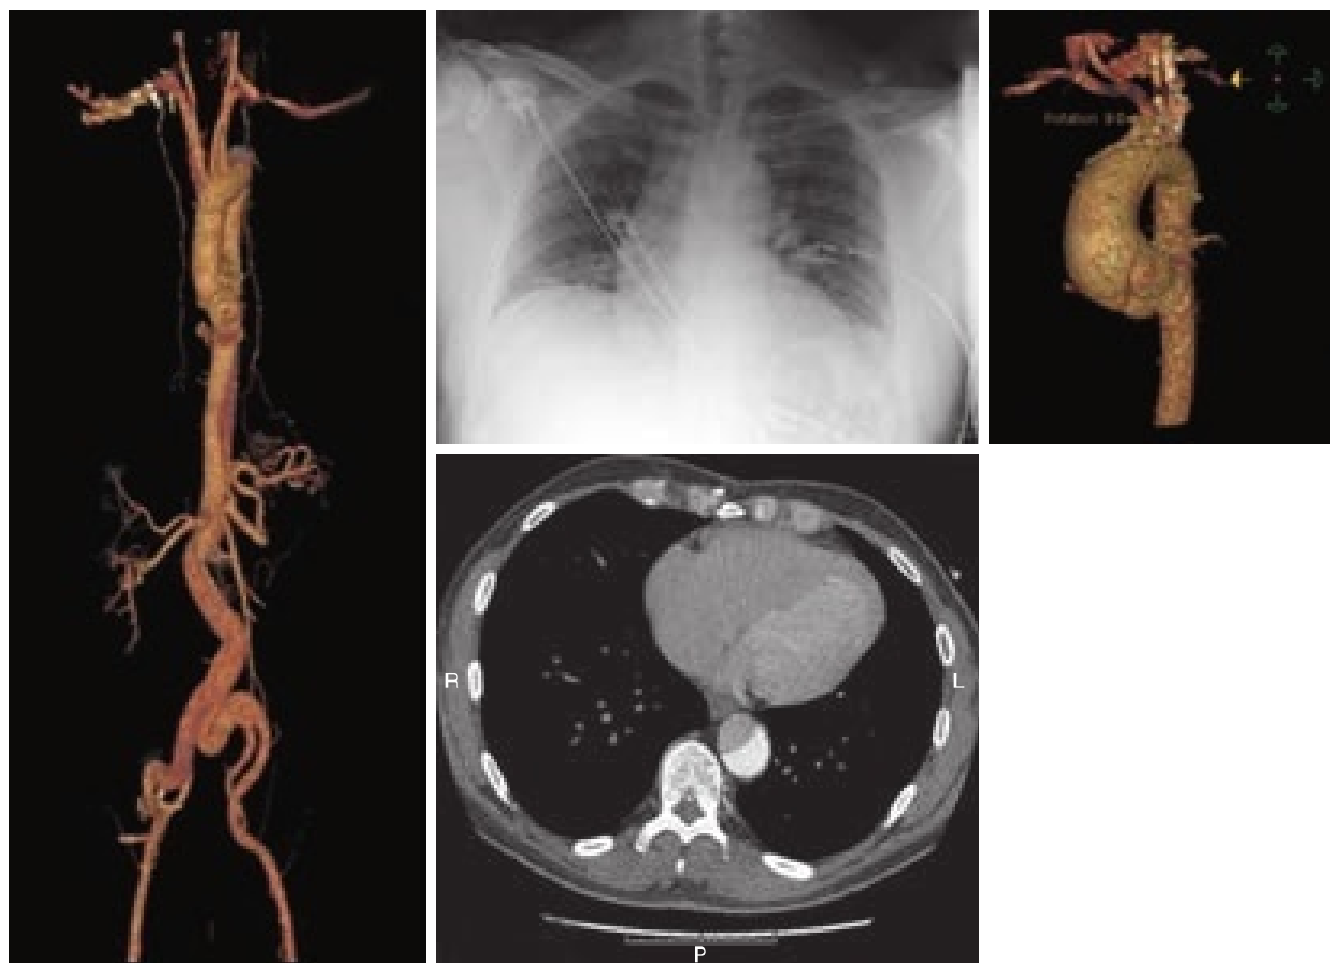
(Clockwise from left) Tomographic reconstruction of a type B aortic dissection, chest radiography showing enlarged mediastinum, and type A aortic dissections seen on image reconstruction as well as with contrast computed tomography scanning.
